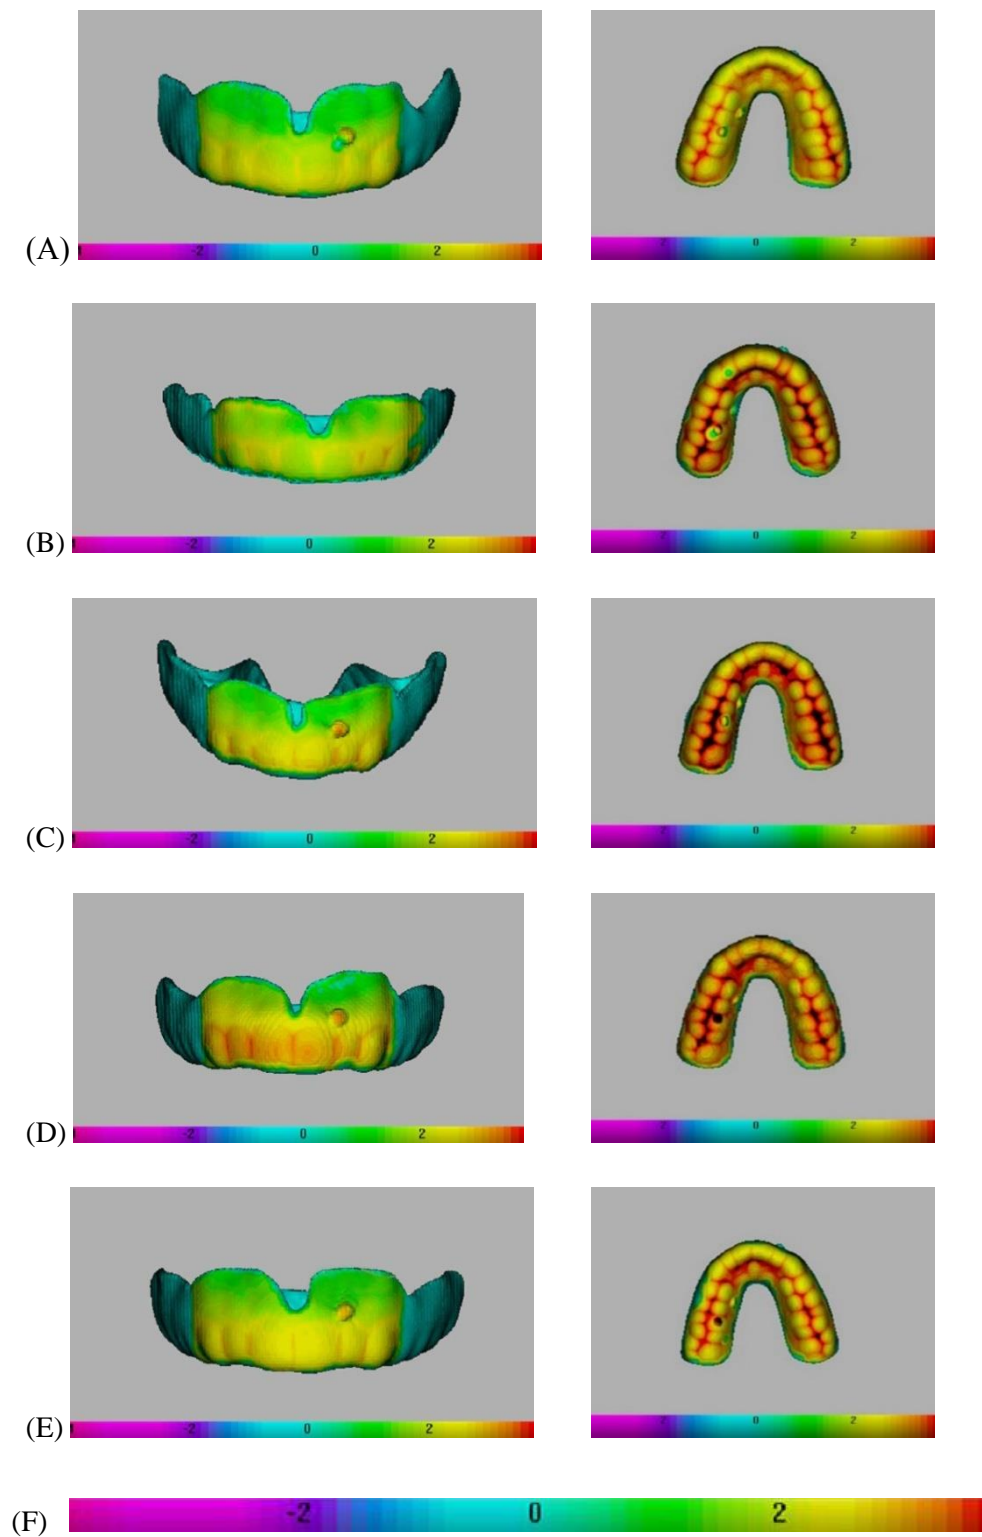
A-E: CT scanned images of the two surface areas within the five thinnest mouthguards. (F) Shows an enlarged thickness/colour key, 0 mm to ± 4 mm.
